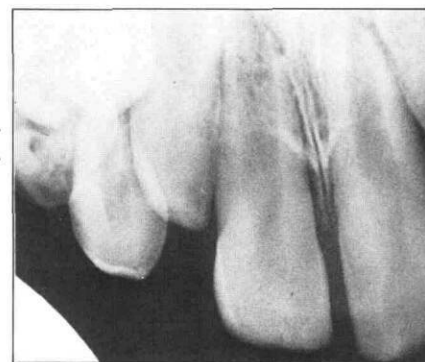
Maxillary periapical radiograph taken at postoperative appointment.
